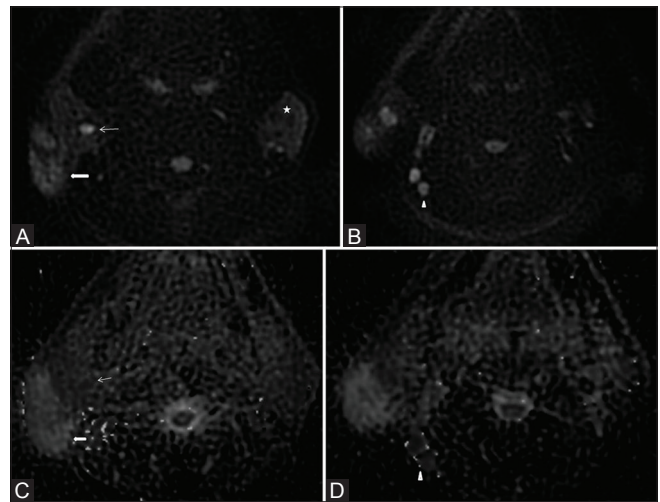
(A-D): Diffusion weighted images and ADC maps. (A and B) The signal intensity of the subcutaneous lesion (*block white arrow*) is higher than the normal parotid gland parenchyma (*star*) on both sides but less than that of the disease associated enlarged right intraparotid (*thin white arrow*) and right posterior cervical (*block arrowhead*) lymph nodes. (C and D) The ADC maps corresponding to the DWI in (A) and (B) show most marked hypointensity (*reduced ADC values*) in the enlarged right intraparotid (*thin white arrow*) and posterior cervical (*block arrowhead*) lymph nodes. Thus, the disease associated enlarged lymph nodes in the Kimura's disease show homogenous diffusion restriction. The subcutaneous lesion (*block white arrow*), however, does not show lower ADC values (*rather appears bright*) than the normal parotid glands and lymph nodes
